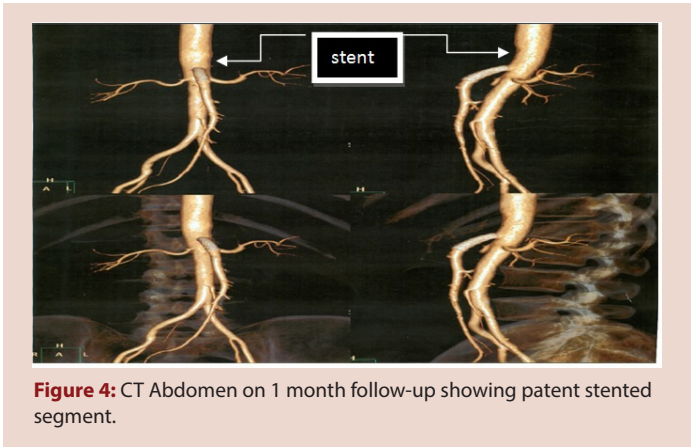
CT Abdomen on 1 month follow-up showing patent stented segment.
